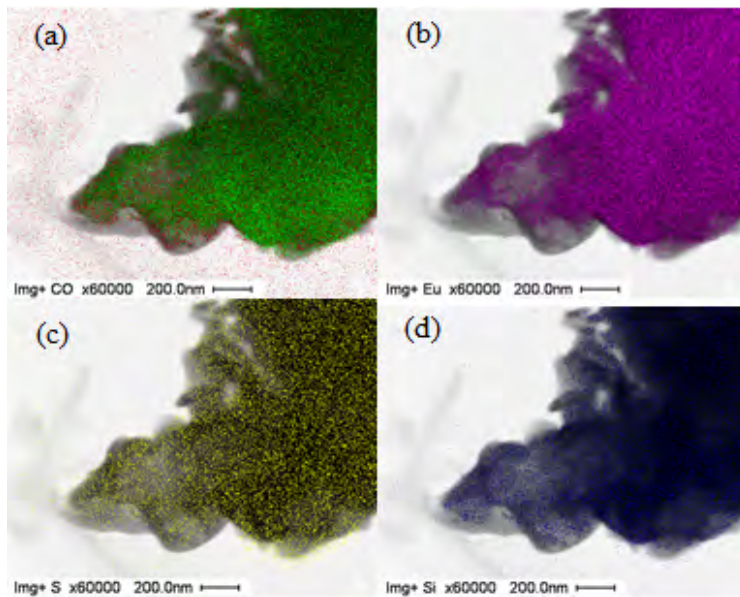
The X-ray map of the europium graphene oxide components: (a) carbon and oxygen, (b) europium, (c) sulfur, and (d) silicon.
